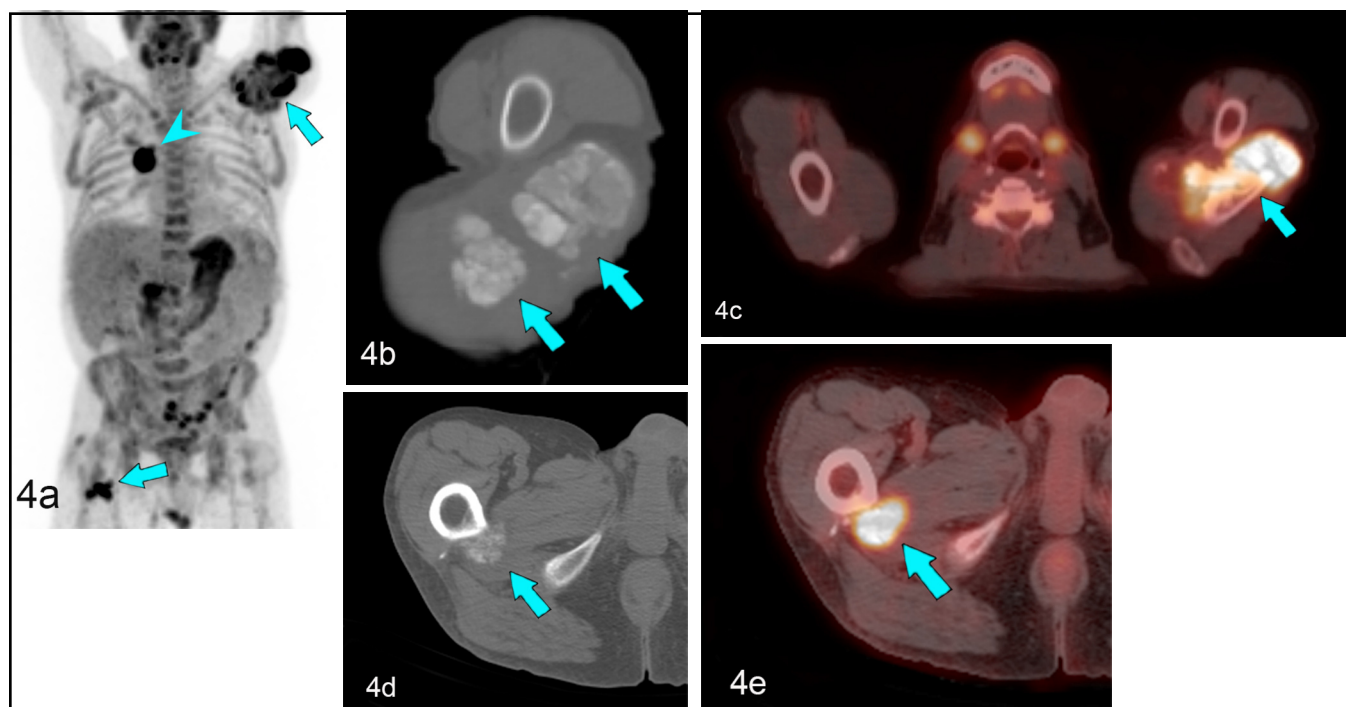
(A) Anterior projection from the PET maximum-intensity projection (MIP) image reveals intense FDG avidity of the mineralized foci at the left shoulder and right hip (arrows). Also present is a right hilar small-cell lung carcinoma (arrowhead). (B) Axial CT image demonstrates the amorphous calcifications at the left shoulder distal to the fracture nonunion. (C) Axial fused image from an F18-FDG PET CT demonstrates avid FDG uptake within the mineralized component. Axial CT (D) and fused image (E) at the right hip shows a mineralized focus at the right lesser trochanter with intense FDG avidity (arrows).
